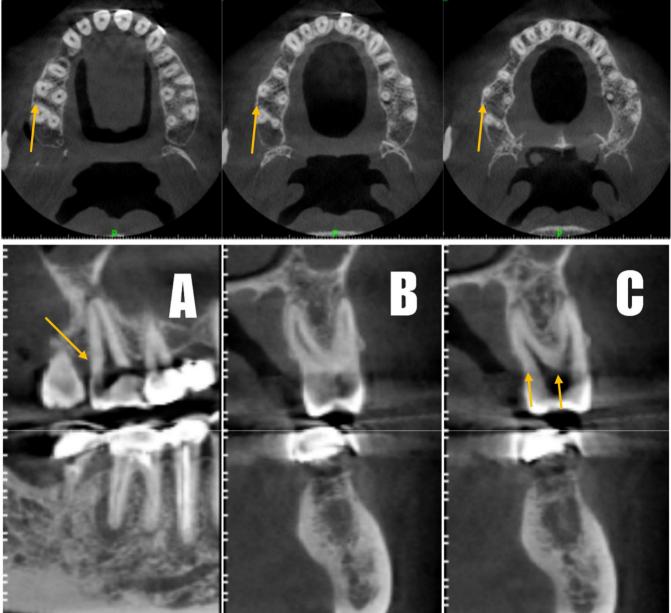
Axial View CBCT; Coronal, Middle & Apical third shows 2 orifices A) Sagittal View showing one root on the buccal aspect of the upper right 1st molar; B & C) Coronal View 2 Roots and 2 canals with Vertucci type 1 Configuration in all aspects.
